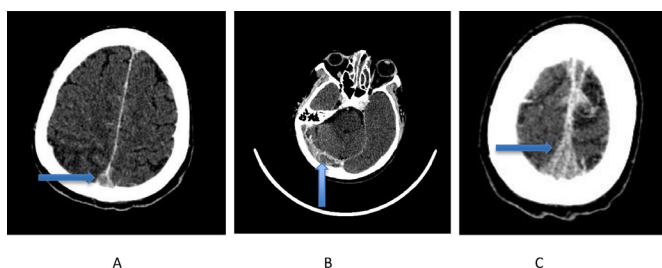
CT venogram images. (A) Empty delta sign suggestive of filling defect in the posterior part of the superior sagittal sinus post contrast administration. (B) Filling defect in the right transverse sinus and the right sigmoid sinus. (C) Filling defect involving the middle part of the superior sagittal sinus.
